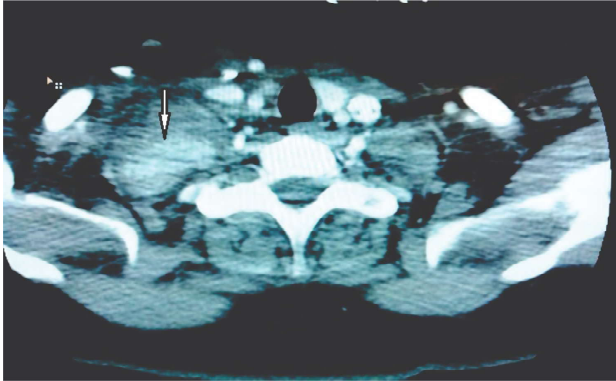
Interim CT angiogram of the neck showing contrast enhancement of the lesion with prolonged uptake.
